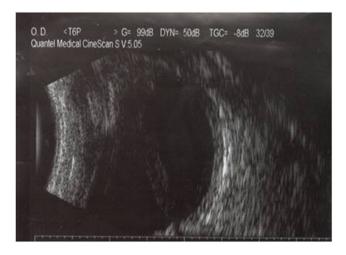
A right eye ultrasound image showing a total retinal detachment contacting the posterior lens capsule.
